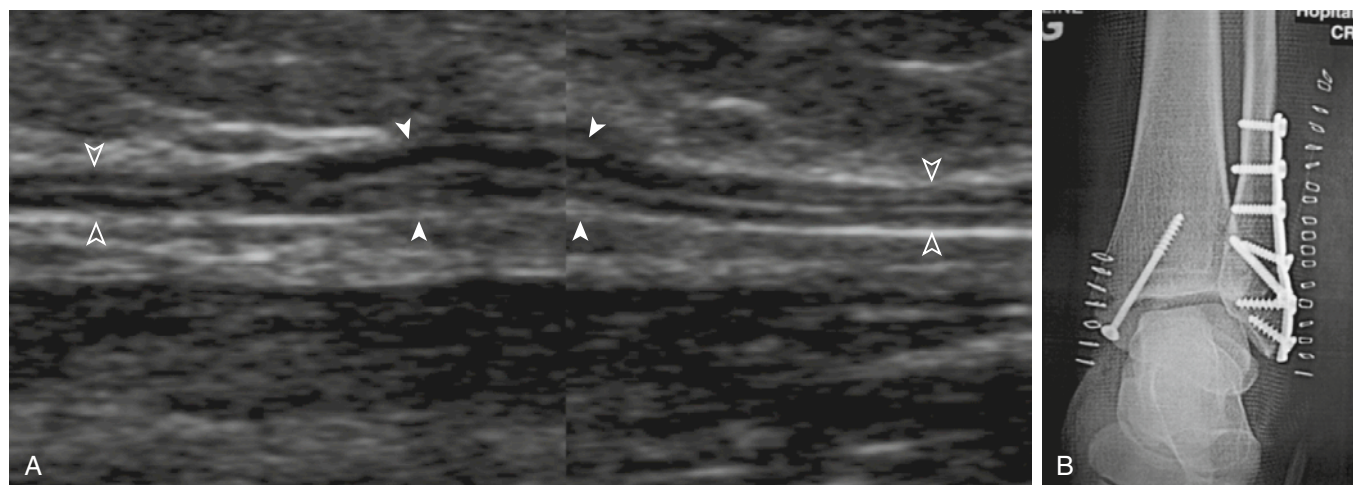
SUPERFICIAL PERONEAL NERVE (SPN) LESION. A woman who had a bimalleolar fracture after an ankle inversion trauma and internal fixation (B) complained of sensory loss in the SPN territory. The composed, long-axis, 5- to 14-MHz ultrasound image (A) over the lateral aspect of the leg at the level of the surgical scar shows a normal proximal and distal SPN (*open arrowheads*) with a very small area of enlarged and disturbed fascicles (*closed arrowheads*) without fascicle interruption. This was caused by local trauma by instruments or stitches during surgery.
